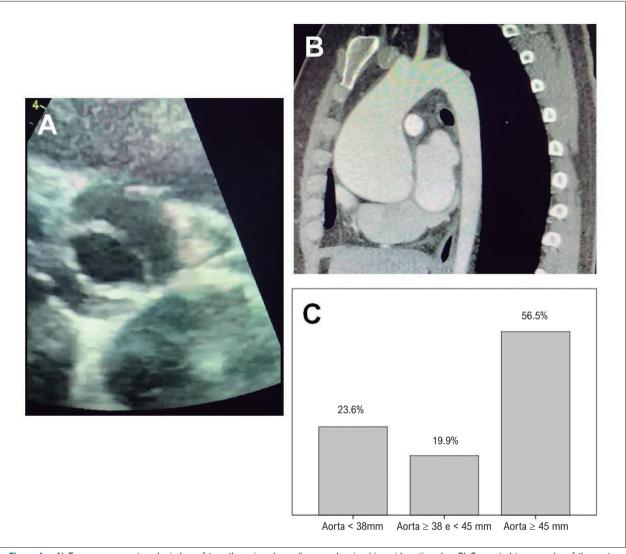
A) Transverse parasternal window of transthoracic echocardiogram showing bicuspid aortic valve. B) Computed tomography of the aorta showing dilation of the ascending aorta. C) Incidence of patients with bicuspid aortic valve and aorta smaller than 38 mm, aorta between 28 and 45 mm, and aorta greater than or equal to 45 mm.
